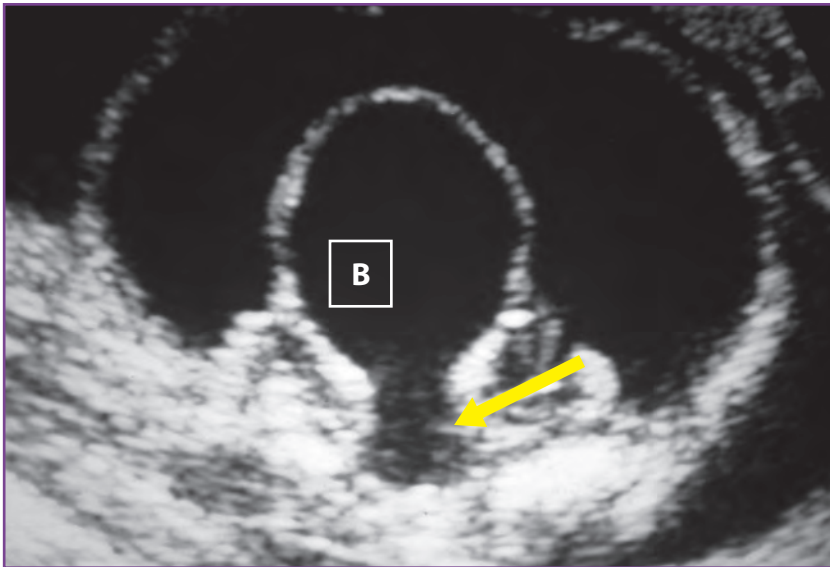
Prenatal ultrasonography demonstrates urinary bladder (B) dilatation and a “keyhole” sign, which represents the dilated posterior urethra (arrow) below the bladder and is suggestive of posterior urethral valves.
